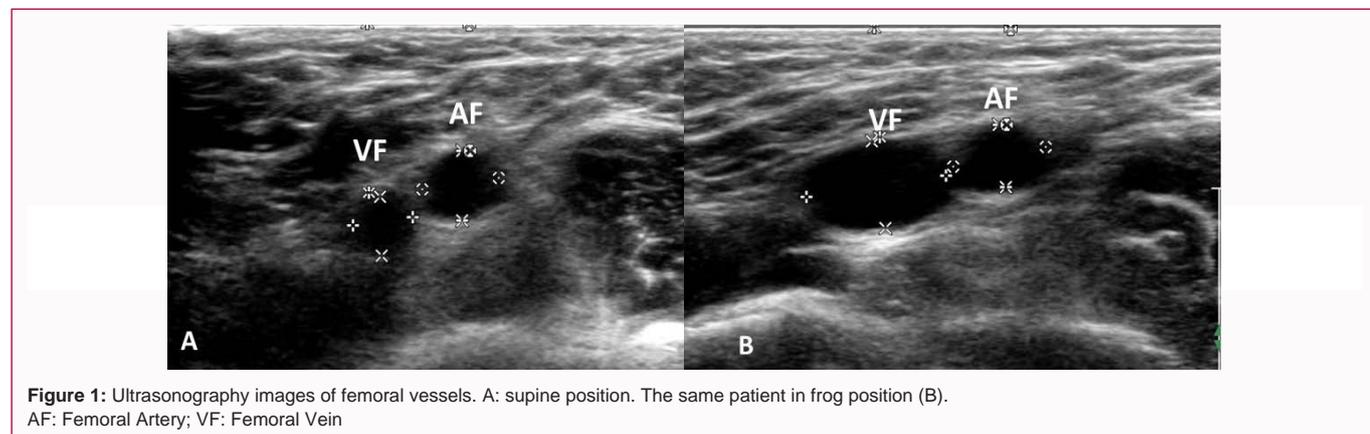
Ultrasonography images of femoral vessels. A: supine position. The same patient in frog position (B). AF: Femoral Artery; VF: Femoral Vein
